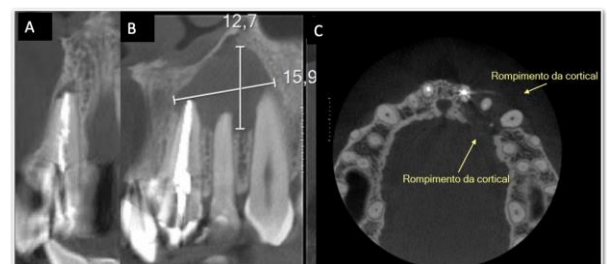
Periapical hypodense area in teeth 11 (A), 21 and 22 (B), and disruption of the buccal and palatal bone cortices (C).
